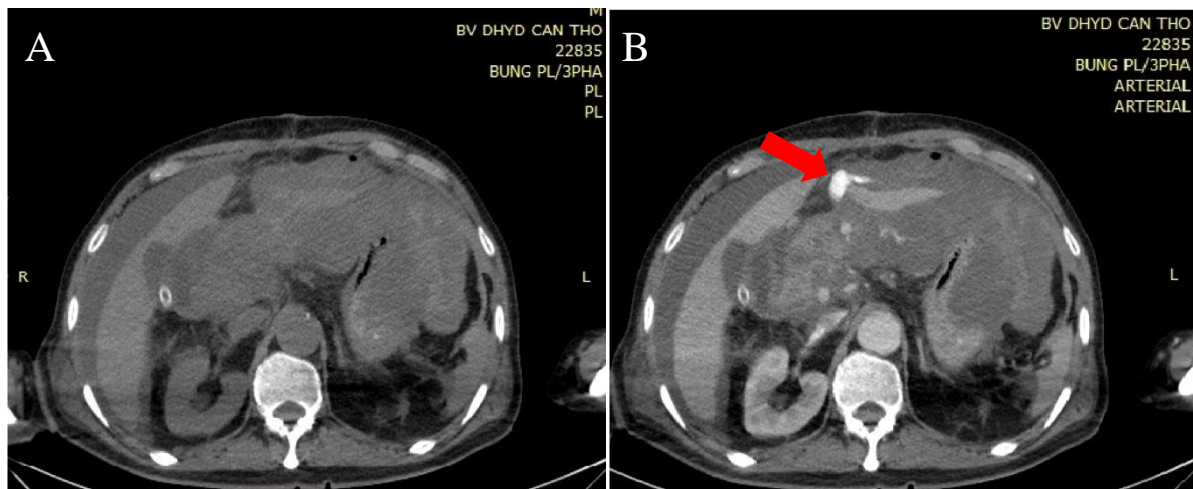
Plain abdominal CT image (A). CT angiography image, showing contrast extravasation, indicating active bleeding (Red arrow, B)
